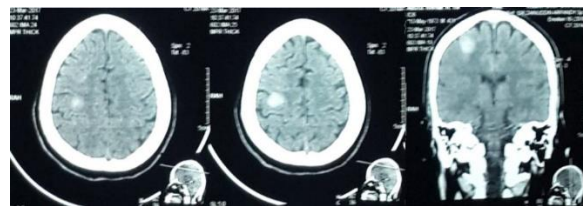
Head CT showing hyperdense nodules in right parietal vertex and left posterior parietal.
